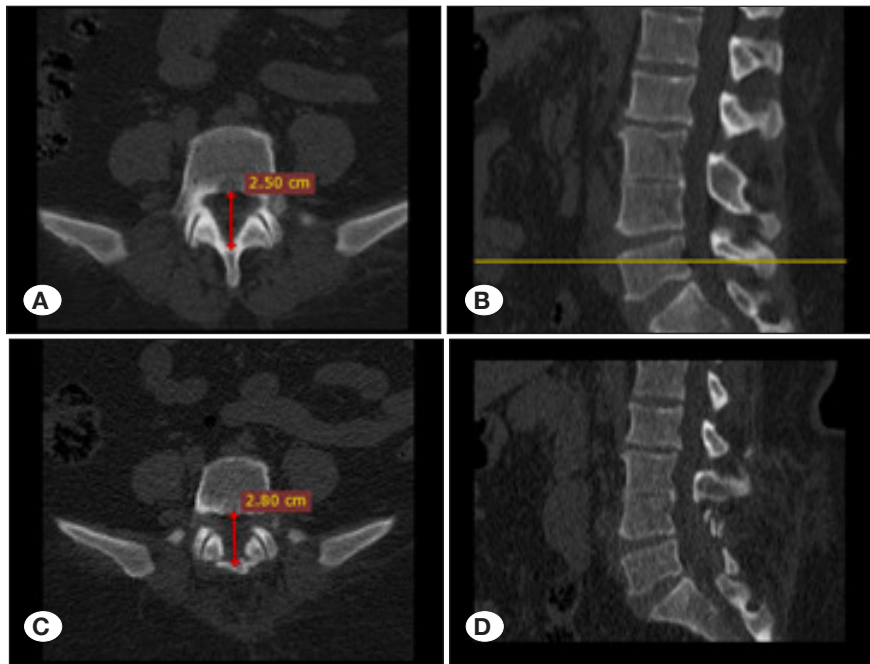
CT images of AP canal diameter measurement. A) Preoperative L5 vertebra axial view AP canal measurement, B) preoperative sagittal view, C) postoperative L5 vertebra axial view AP canal measurement, D) postoperative sagittal view.
